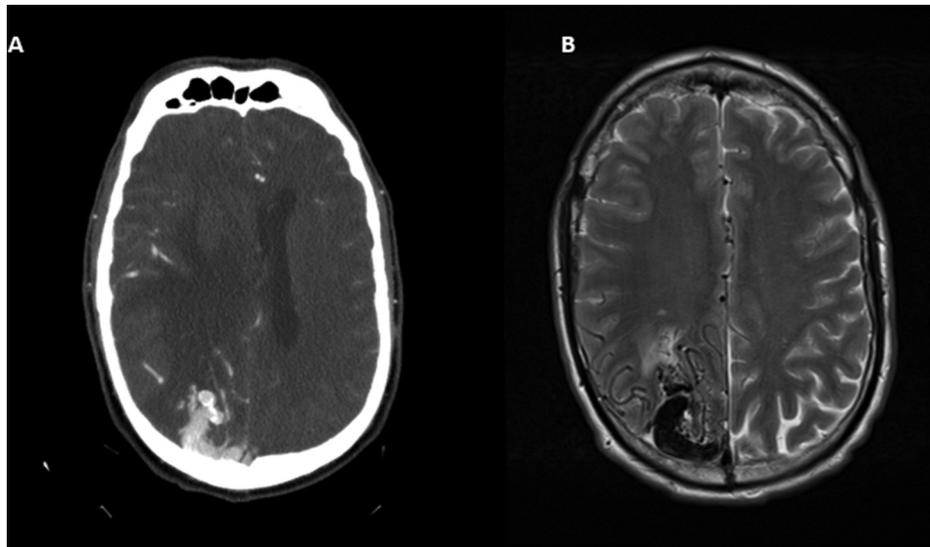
A. Axial CT angiogram with contrast. B. Axial T2 MRI: AVM of the temporal parietal lobe with prominent draining vein.
